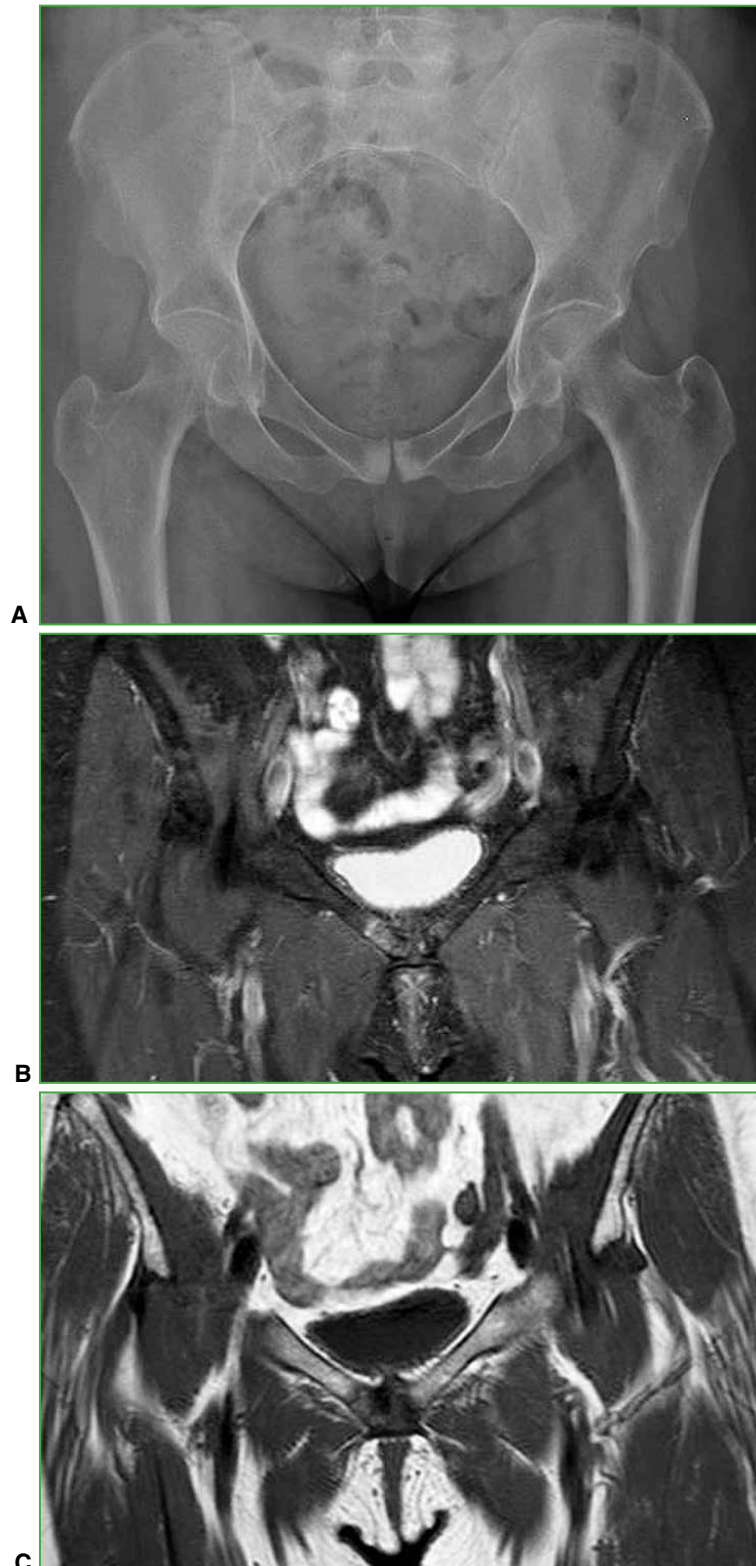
A 72-year-old woman. A. Anteroposterior pelvis radiograph. An increase in radiopacity is observed in both pubic rami. B. Pelvic MRI, coronal plane, STIR sequence. Bone edema is visualized in the right pubic ramus. C. Pelvic MRI, T1-weighted sequence. The hypointense fracture trace is observed.
